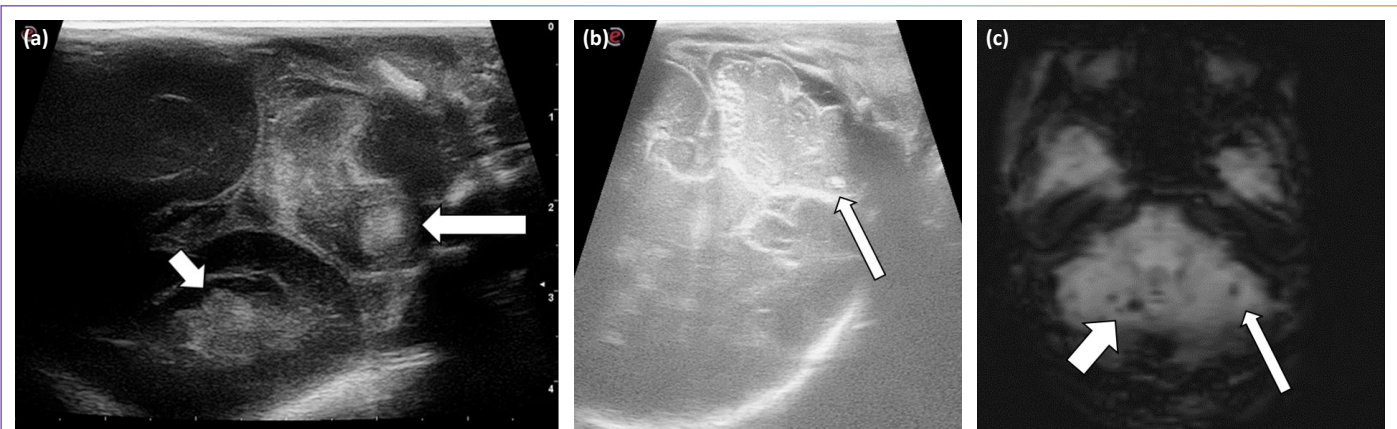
MF-CUS examination of a 28-week-old newborn identifies a left cerebellar parenchymal hematoma (long arrow) and hemorrhagic materials in the occipital horn of the lateral ventricle (short arrow) (a). MF-CUS examination of a 36-week-old newborn shows a left cerebellar parenchymal millimetric hematoma (b). In the same patient, SWI sequence MRI shows signals of millimetric hemorrhages in the other hemisphere in addition to the hematoma observed in MF-CUS (c).
